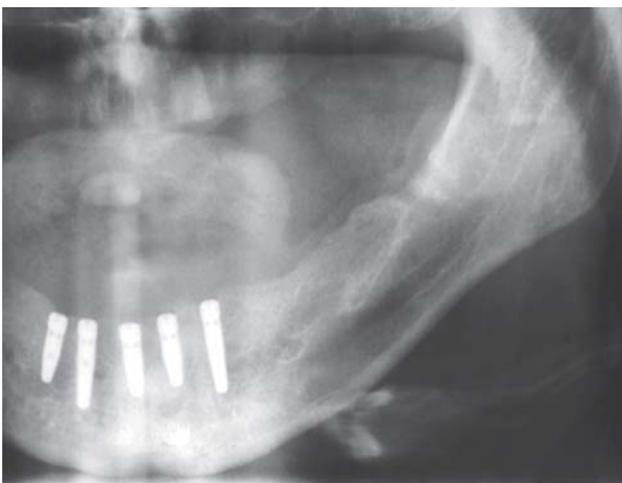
Panoramic radiograph of the mandible demonstrates successful osseointegration of five fixtures
